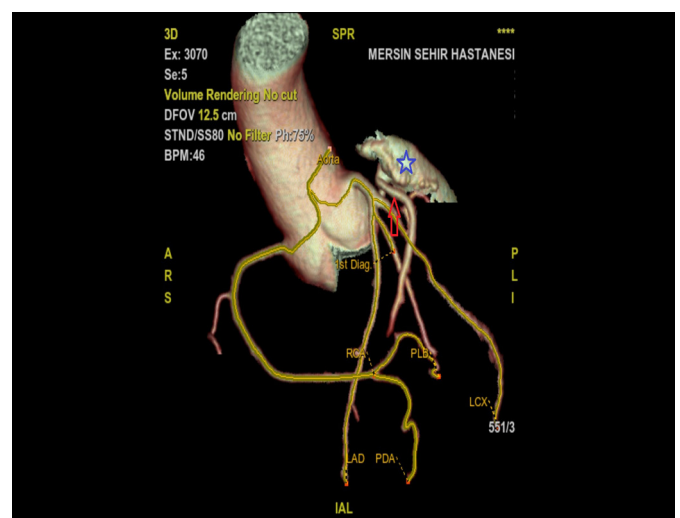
Case 1. Three-dimensional volume-rendered CT image in a complementary projection. Blue star: LAA; red arrow: GCV; green arrow: left main coronary artery
